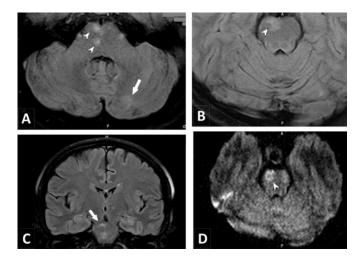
MRI images of the patient. (A) and (B) Hyperintense lesions in T2 FLAIR axial images at the level of pons (arrowheads) and subtle hyperintensity in the left cerebellum posteriorly (arrow); (C) Lesions in pons (arrow) on T2 FLAIR coronal section; (D) Diffusion restriction in the pontine lesion (arrowhead) on diffusionweighted image.
